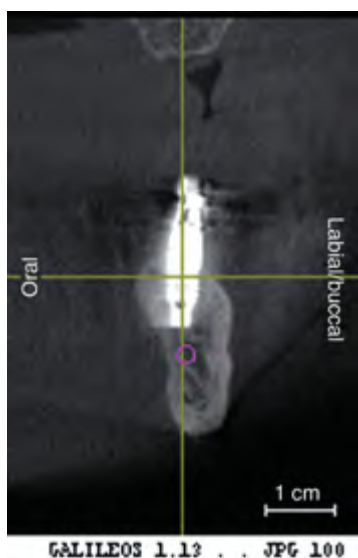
Radiograph of the right posterior implant 1 week post implant placement. The postoperative position corresponded with the virtual planned position in the diagnostic phase.
